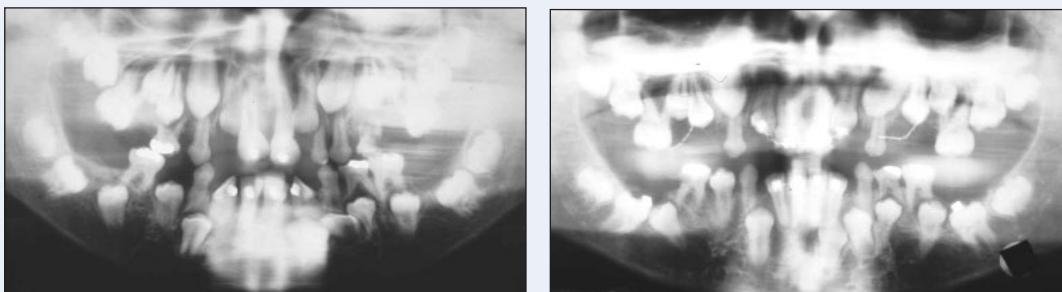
Panoramic radiograph at the start of treatment.
